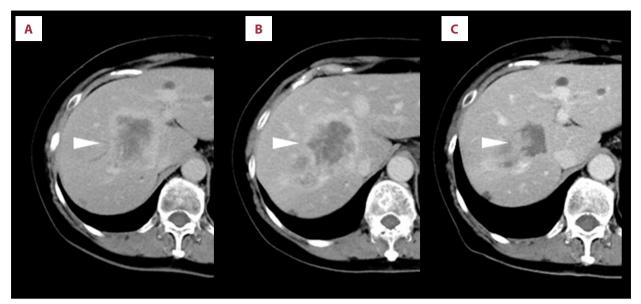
Changes in newly developed liver metastasis on E-CT imaging. Twenty-five years after surgery, E-CT (A) revealed newly developed liver metastasis (white arrowhead). E-CT after administration of eribulin mesylate for 8 months showed no reduction in liver metastasis (B). E-CT images after receiving 30 cycles of RF hyperthermia (C) (white arrowheads) showed liver metastasis that gradually reduced.
